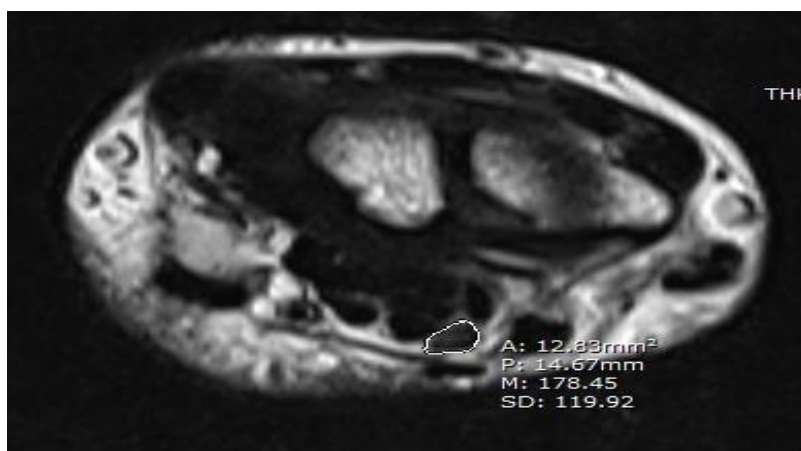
Axial T2-weighted MR image of the right wrist at the level of the carpal tunnel demonstrating mild diffuse thickening of the median nerve with increased signal intensity, loss of normal fascicular definition and an increased cross-sectional area (12.8 mm²), suggestive of inflammatory neuropathy.
